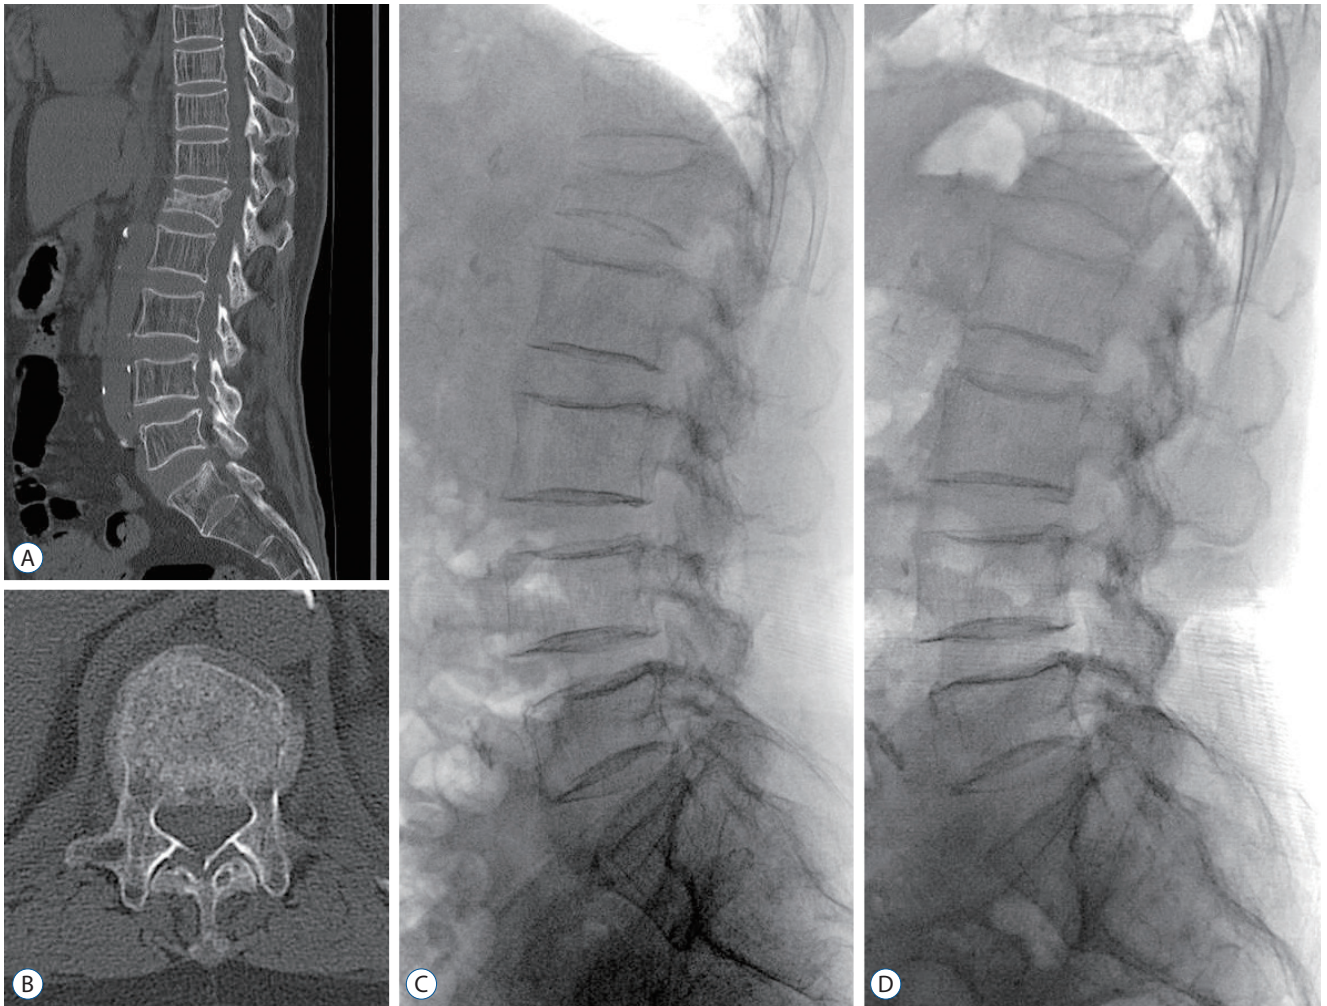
A 70-year-old female patient with a L1 burst fracture (thoracolumbar injury classification and severity score 5 and McCormack's load sharing score 7) was treated conservatively using teriparatide because of severe chronic obstructive pulmonary disease. Sagittal (A) and axial (B) view of computed tomography at baseline shows L1 burst fracture with $\geq 50\%$ of compression ratio and posterior column involvement. Lateral plain X-ray at 12-month (D) shows similar radiological features compared to baseline (C).
